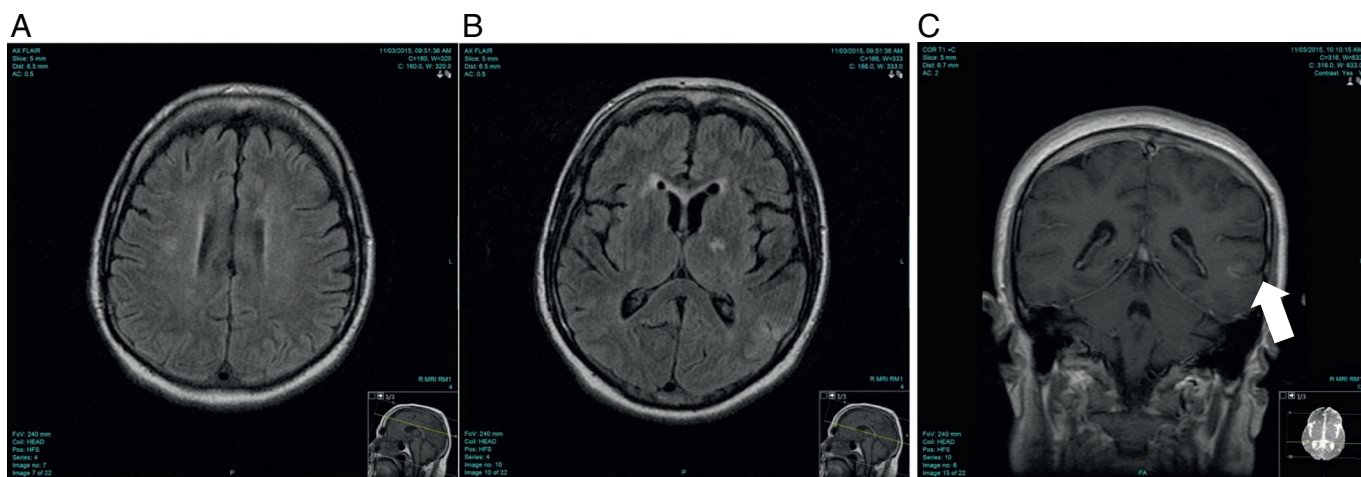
MRI images at presentation A: Brain MRI FLAIR axial image showing a focal area of hyper intensity in the right peri ventricular white matter and corona radiata B: Brain MRI FLAIR axial image showing cortical and subcortical hyper intensity in the left parietal lobe C: Brain MRI T1 post contrast coronal image showing corresponding cortical enhancement of the left parietal lesion.
